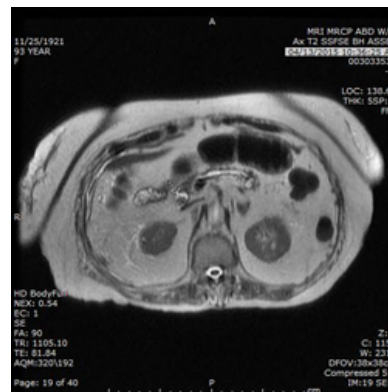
MRI MRCP ABD W/O (Ax T2 SSFSE BH Asset).
